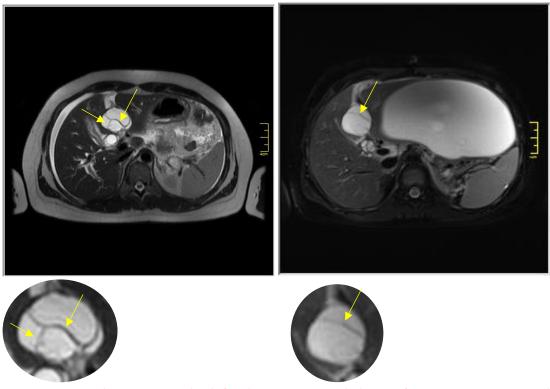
Baseline MRI study (left) showing an oval shape of MCN-L as compared to a more circular one (right) following its rupture. Some differences regarding the pattern of internal septations are also visible.
